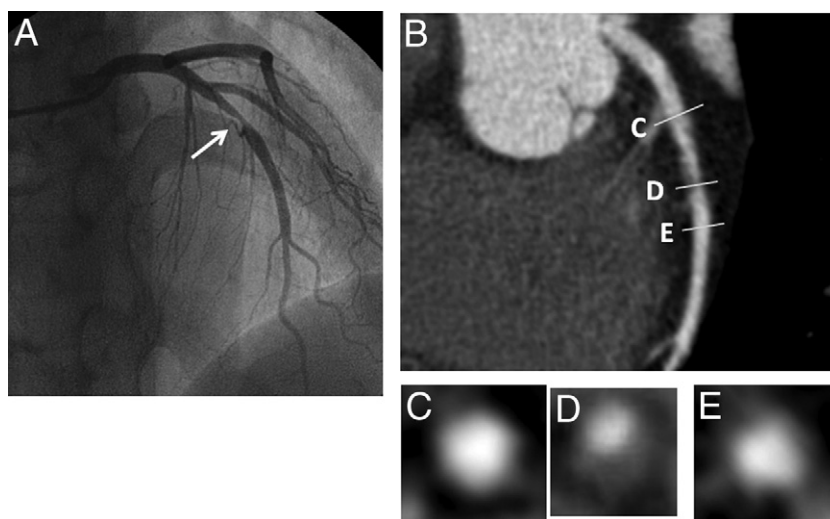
CT Characteristics of Culprit Lesion in Patient Without Post-PCI TnT Elevation ≥ 3 Times Upper Limit of Normal
